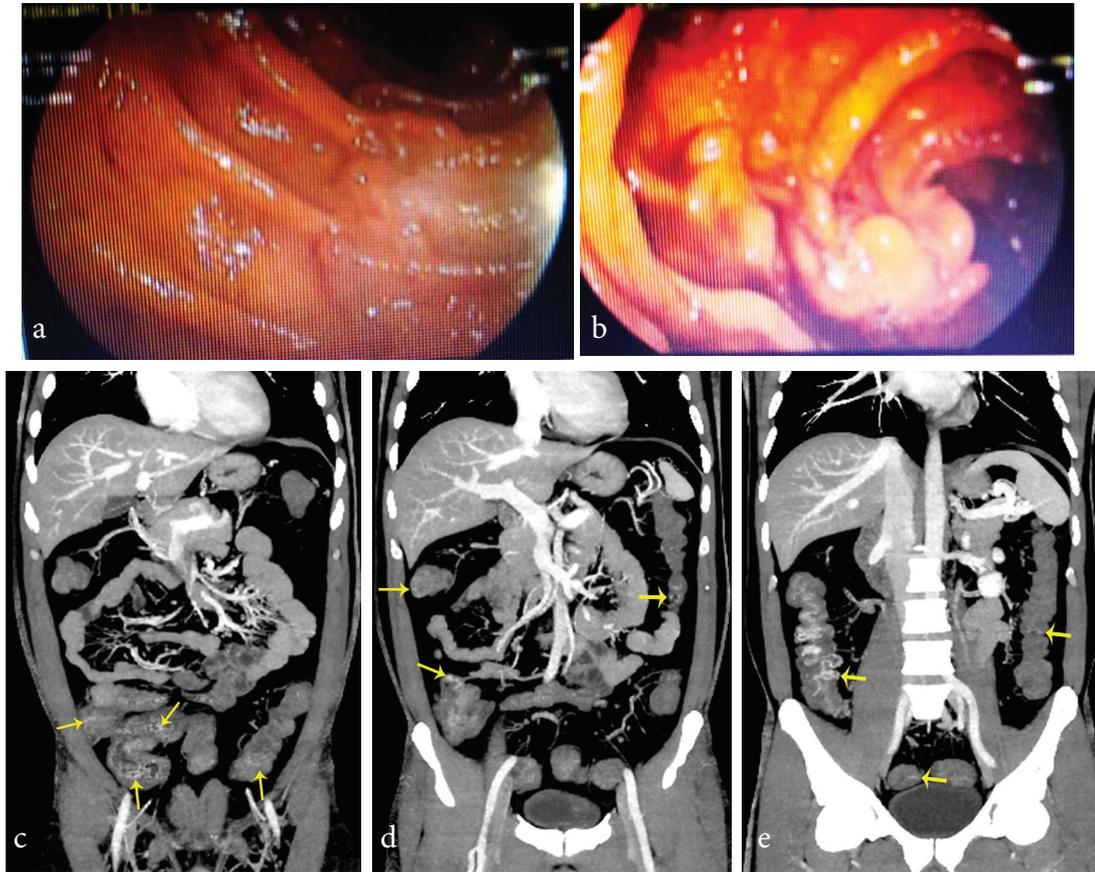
(a and b) Images demonstrate submucosal varices on colonoscopy. (c-e) Coronal reformatted images from a triphasic CT scan demonstrate dilated submucosal veins in the colonic segments (arrows).
